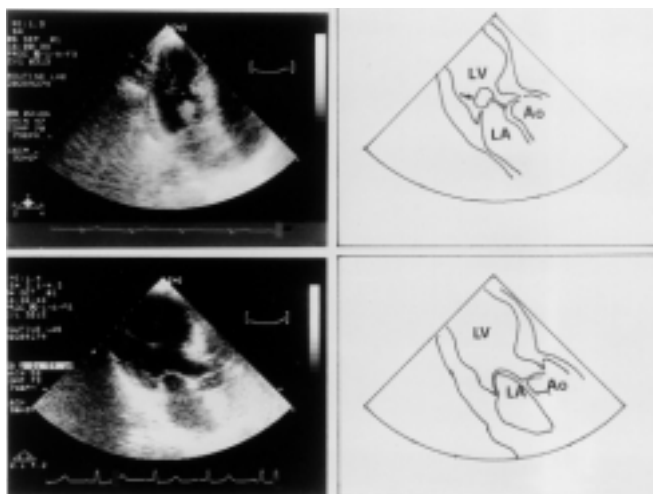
Echocardiogram shows vegetation over mitral valves (upper); no vegetation found after antibiotics treatment for 4 weeks (lower).
